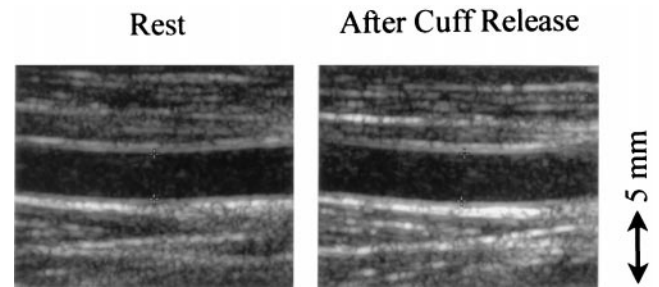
Representative example of ultrasound images of brachial artery at rest (left) and 60 s after cuff release (right). The diameter of the artery increased from 3.22 mm (rest) to 3.48 mm (after cuff release) in response to increased blood flow. In this case, the percentage of flow-mediated dilation was 8.1%.
